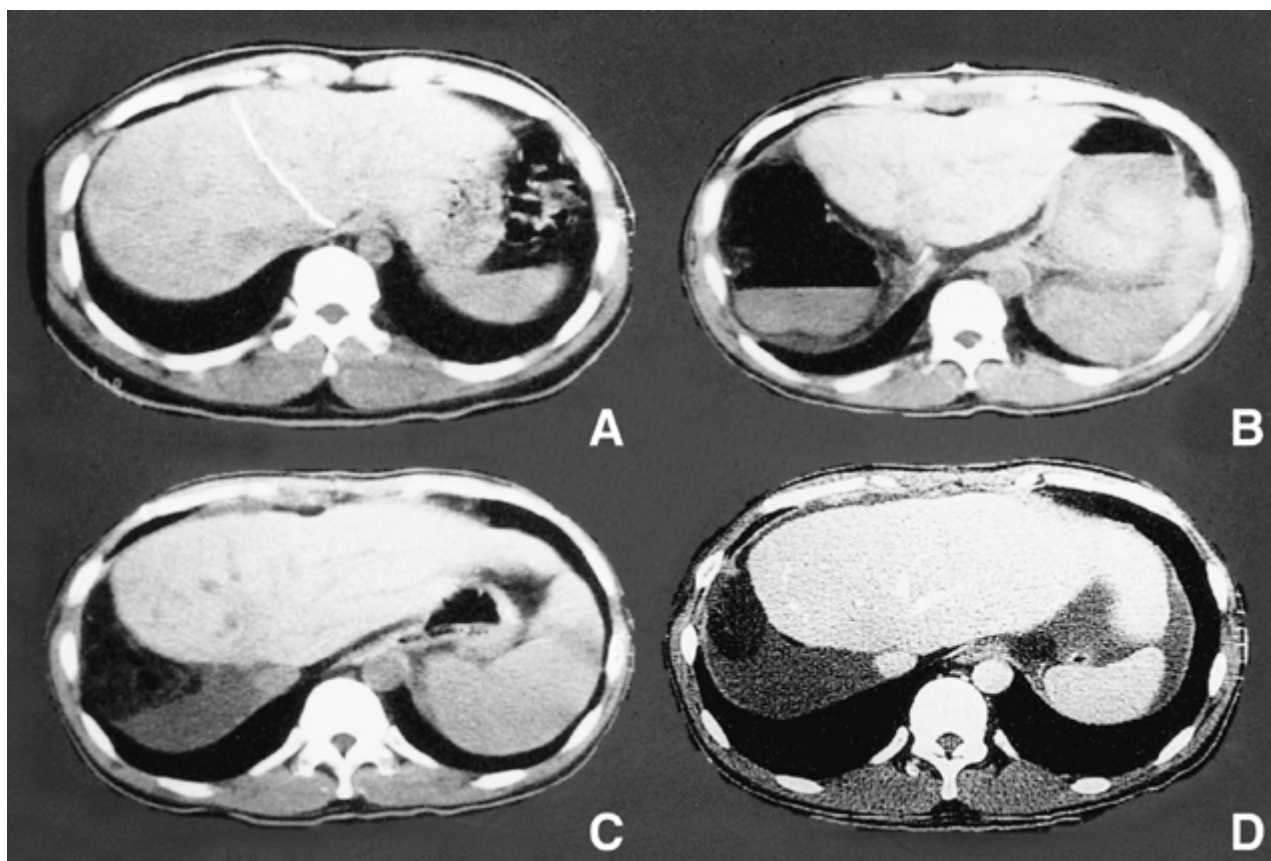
Computed tomographic scans of donor and recipient after adult-to-adult living donor liver transplantation. A) Donor's liver, 375 g of left lobe graft; B) 587 ml liver volume 1 week after transplantation; C) 818 ml liver volume 3 weeks after transplantation; D) 923 ml liver volume 2 months after transplantation.
